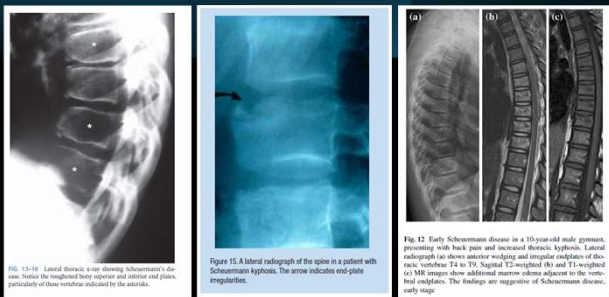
Lateral thoracic x-ray showing Schmorl's disease, namely the impinged bony superior and inferior end plates, particularly of those vertebrae indicated by the arrows.
